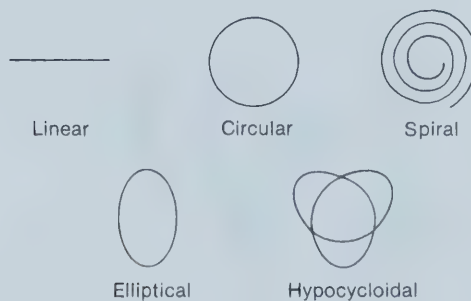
Types of X-ray Tube Motion in Tomography. Note that the types of tomography are listed in order of increasing tube-film movement complexity. The more complex the tube-film movement is, the greater the ability to blur adjacent anatomy. (From Goaz PW; White SC 1994; 13: 267)
